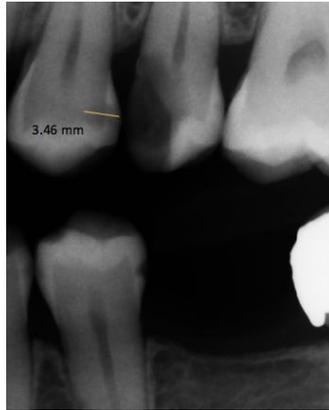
Bitewing radiograph image shows the radiographic measurement of an approximal caries lesion depth
